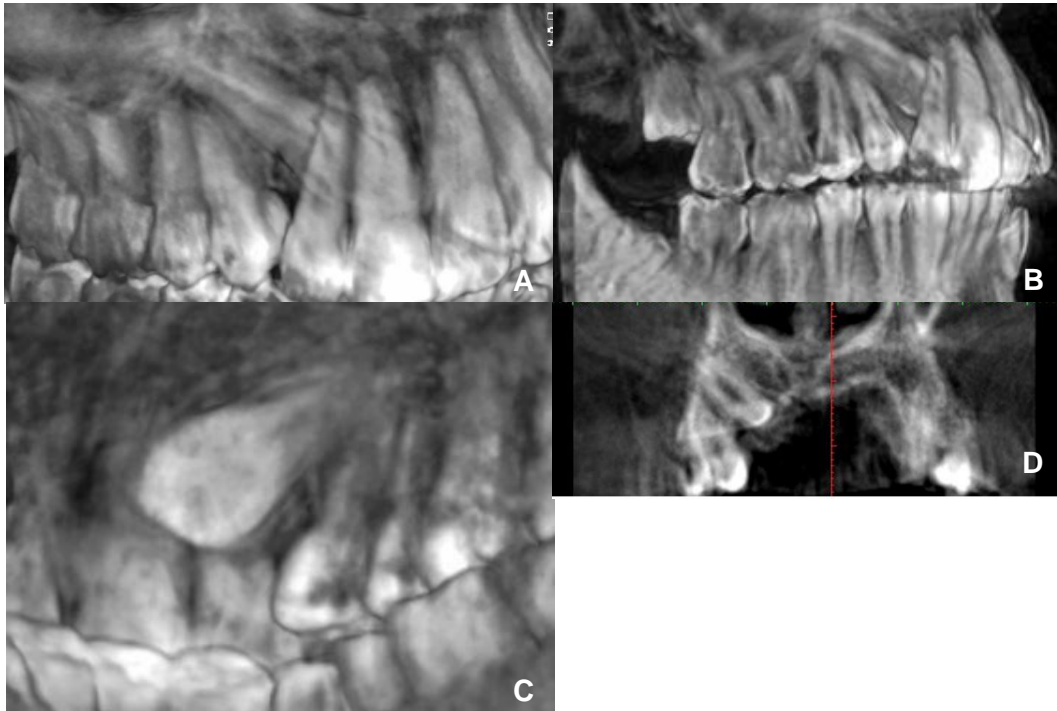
CBCT image. Root resorptions and dilacerations weren't found. A) vestibular view of the 3D reconstruction image, B) position of the apex near to the 2nd premolar, C) crown positioned palatally in relation to the maxillary incisors and D) coronal view.
